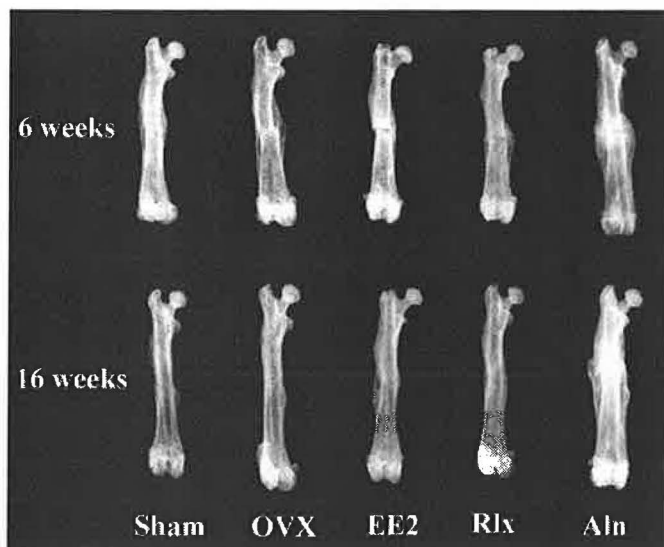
Soft X-ray radiographs of fractured femora. External callus formation was visible in all femora at 6 weeks. Fracture lines disappeared in OVX at 16 weeks, 56% fracture lines were still visible in ALN at 16 weeks.
